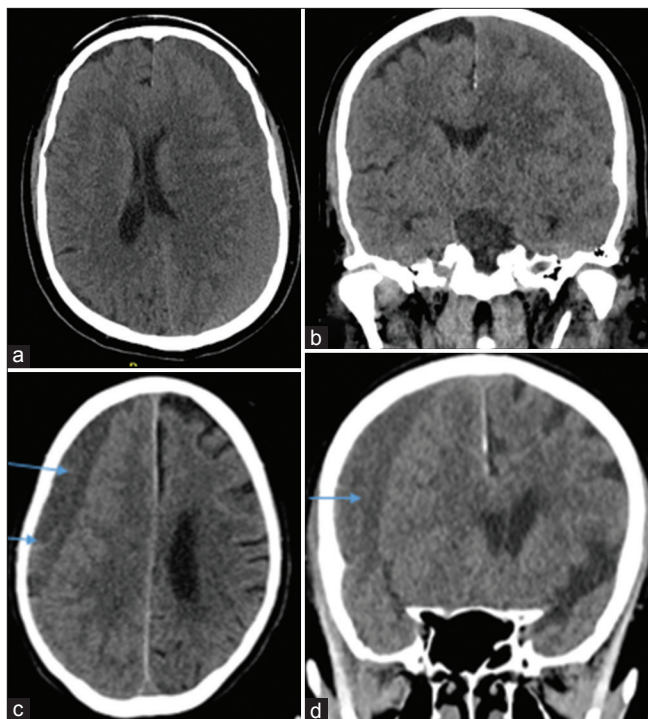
(a and b) Computed tomography (CT) scan axial and coronal images of a middle-aged patient with a single compartment left chronic subdural hematoma. (c and d) CT scan axial and coronal images of another middle-aged patient with a multi-compartmental right chronic subdural hematoma (arrows highlight membranes).
